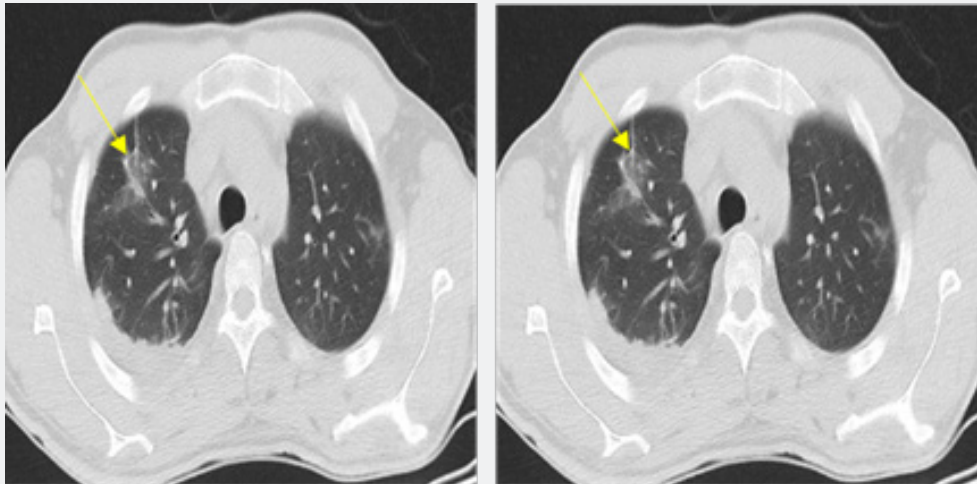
A contrast - enhanced computed tomography chest showing ground - glass opacities.
